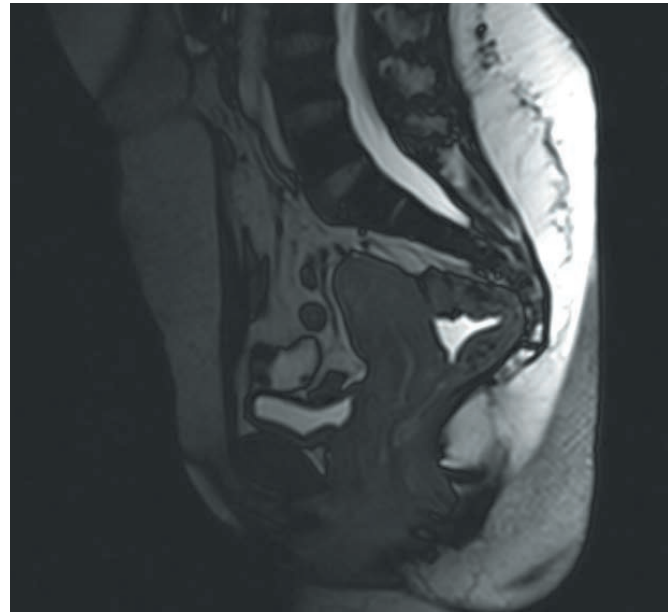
Six-month follow-up sagittal magnetic resonance imaging scan demonstrating a normal endometrial stripe and markedly reduced fibroid burden.
